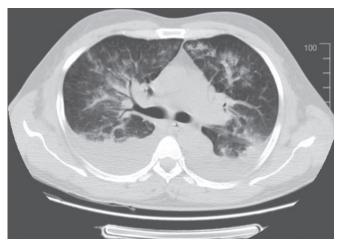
High resolution computed tomography chest done at 1st week of admission showing multifocal peribronchial air space opacifications with ground glass opacification in bilateral upper and right middle lobe with pleural effusion
